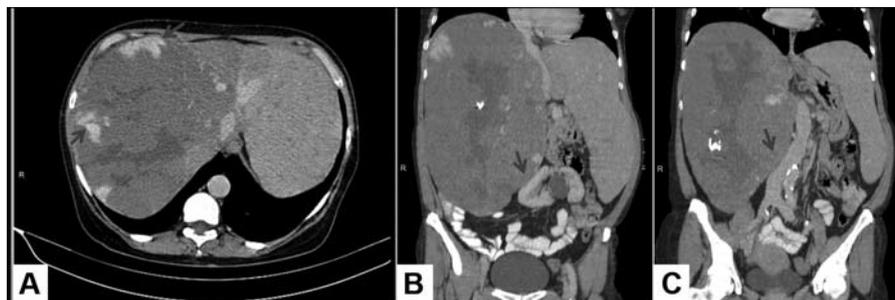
Computed tomography of the abdomen in axial view revealed a giant hemangioma in the right hepatic lobe, with specific progressive centripetal iodophilia (arrows) during venous/delayed phase (A). Compression of the kidney (arrow) (B) and cava vein (arrow) (C) was also apparent in the coronal view.
